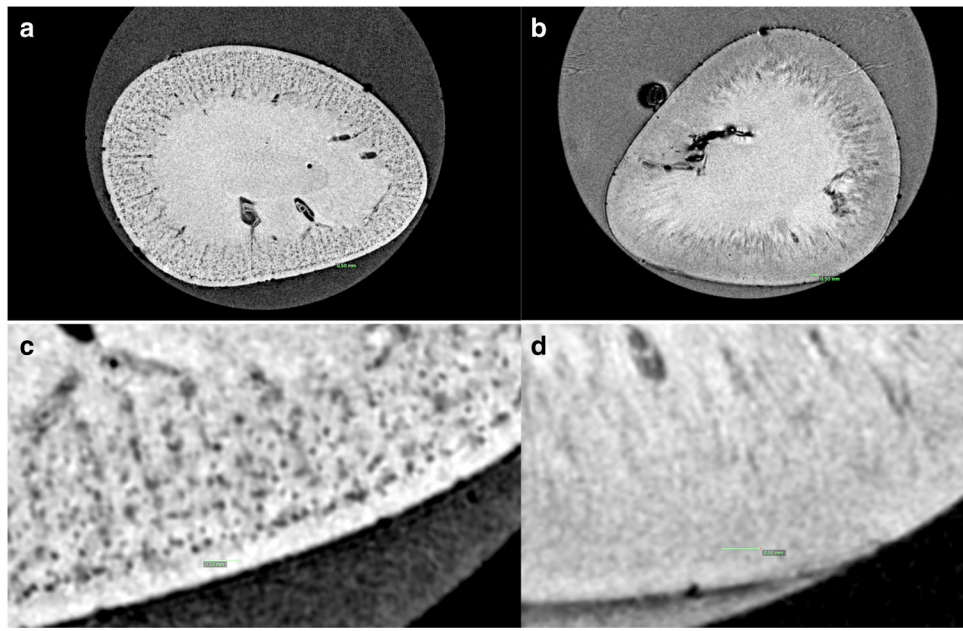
Representative MR image of cationic ferritin enhanced MRI (A) and control without cationic ferritin (B).
